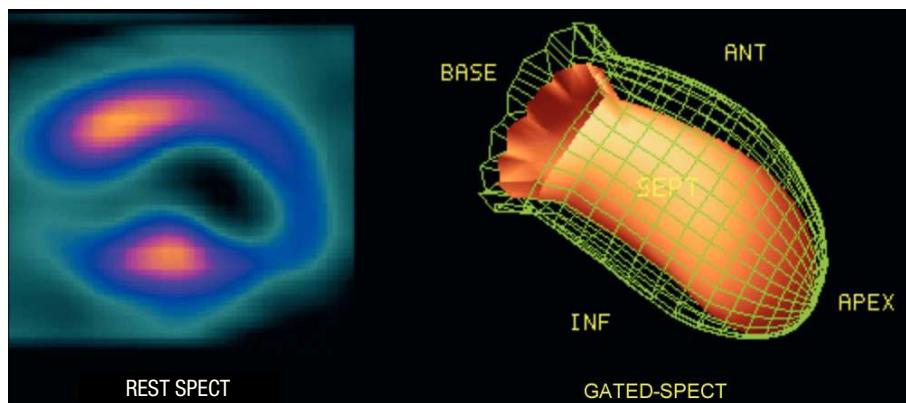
SPECT images of myocardial perfusion at rest (vertical long-axis view) of a patient with anterior infarction and criteria of myocardial viability. The apical akinesia region (right) indicates to moderate (grade 2) perfusion uptake defect (left). End-diastolic volume, 123 mL; end-systolic volume, 81 mL; ejection fraction, 34%. Ant indicates anterior; Inf, inferior; SPECT, Single-Photon Emission Computed Tomography.
